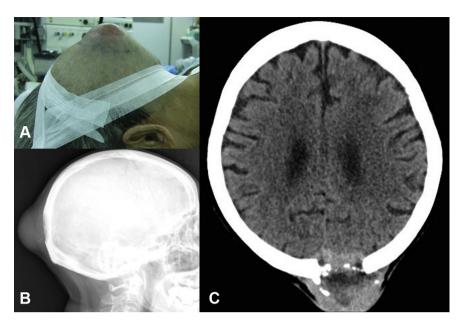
(A) Lateral view of the head demonstrates a scalp mass. (B) Plain radiography of the skull depicts an osteolytic defect in the occipital bone. (C) Computed tomography reveals a defect in the left occipital bone and a soft mass compressed the superior sagittal sinus.
